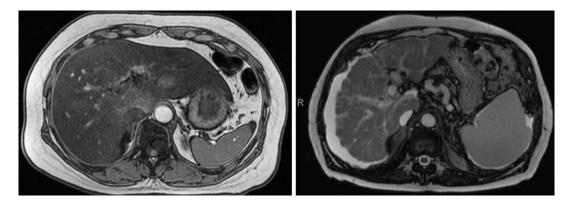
Abdominal MRI in T1 weighted images demonstrating healthy liver parenchyma (left) and micronodular cirrhosis and ascites (right)
